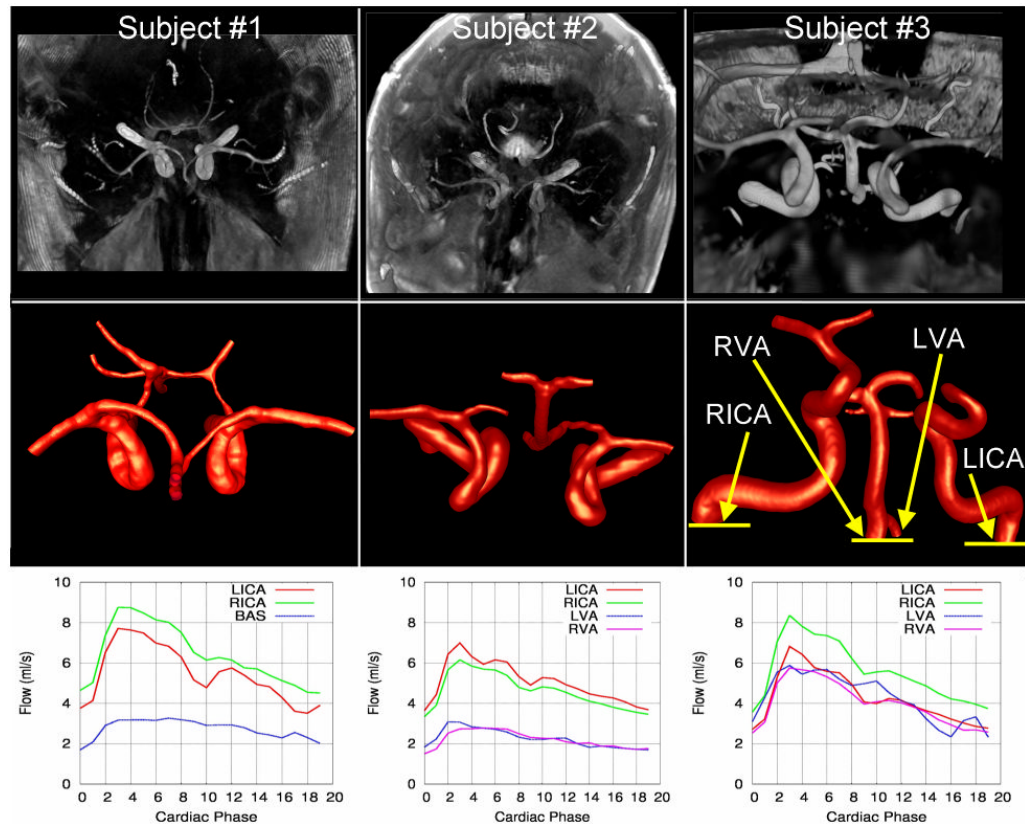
Magnitude PC-MR images (top row), corresponding vascular models (center row), and flow rate waveforms at the inflow vessels of three normal subjects. Subjects 1 and 2 are shown from a superior-inferior view and subject 3 from an anterior-posterior view.
